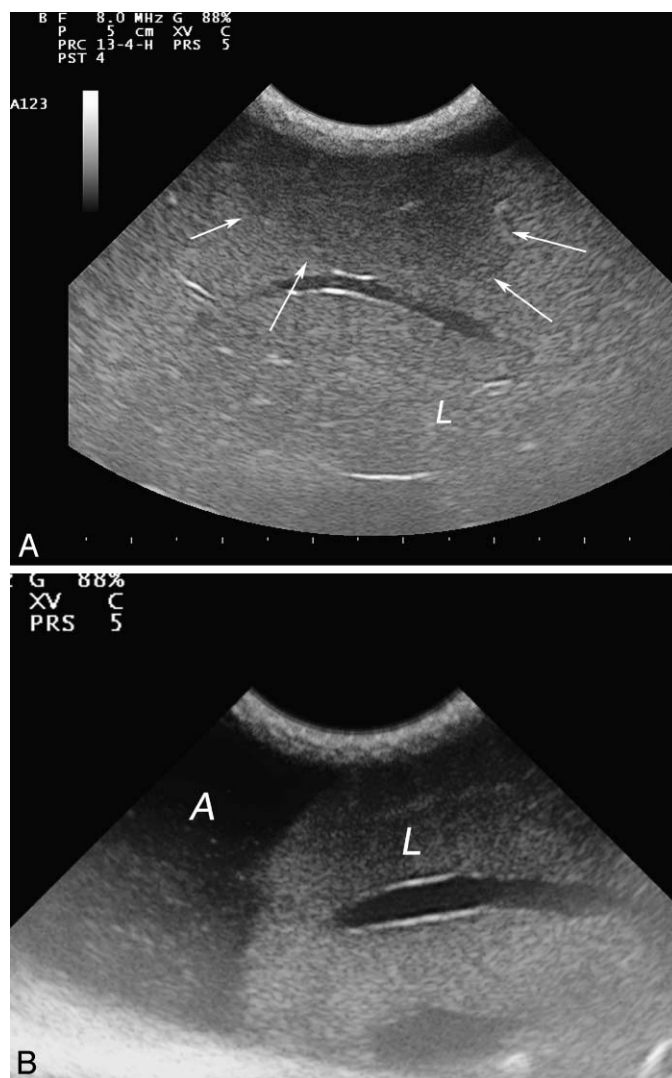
(A) Ultrasound image of the liver (short axis section). Hepatomegaly with areas of increased and decreased (white arrows) echogenicity. L = liver. (B) Ultrasound image of the liver (long axis section). Hepatomegaly with increased echogenicity and surrounding ascites. L = liver, A = ascites.
